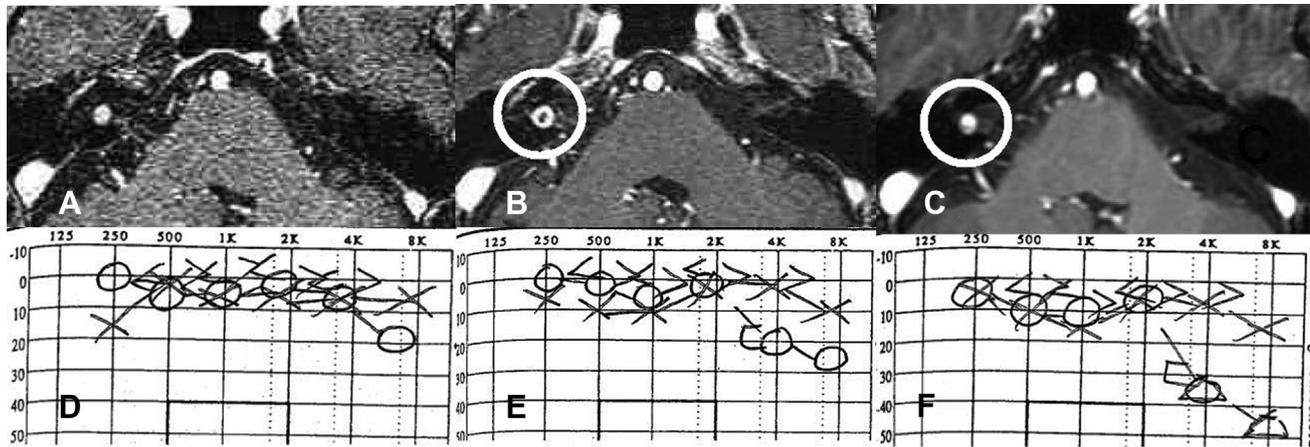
Serial magnetic resonance imaging (MRI) of a 55-year-old man with a tiny vestibular schwannoma (VS). (A) Axial MRI at the time of Gamma Knife radiosurgery (GKRS) demonstrating a tiny VS in the right internal acoustic canal. (B) Follow-up MRI shows normalization of the tiny VS without enlargement, and the central hypointensity has disappeared. The comparable pure tone audiogram checked around the time of the aforementioned MRI studies showed no significant changes in 500–4k but a decline in some high-pitched sounds. Images (D), (E), and (F) correspond with images (A), (B), and (C), respectively.
